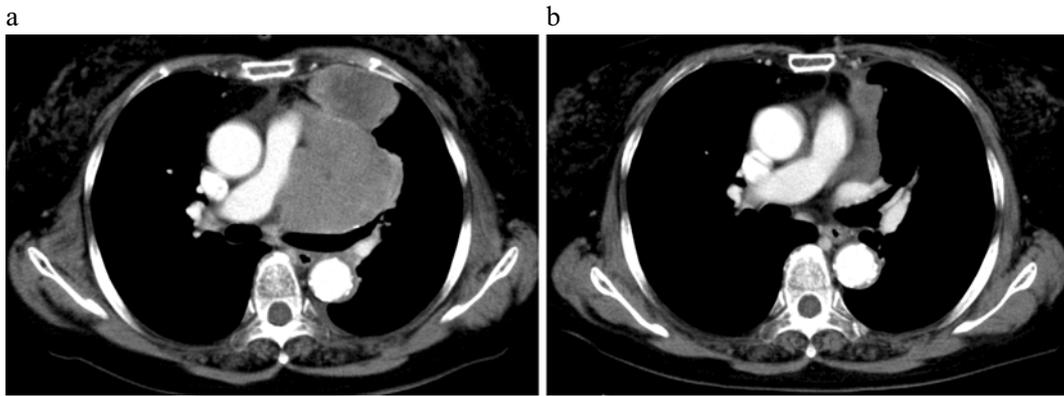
Computed tomography (CT) image of the chest. CT at the initial admission showing a mass in the left upper lobe (5 cm in diameter) and a mediastinal lymph node (8 cm in diameter) (a), and CT five weeks after chemoradiotherapy showing reductions in the size of the lung and mediastinal lymph node masses (b).
